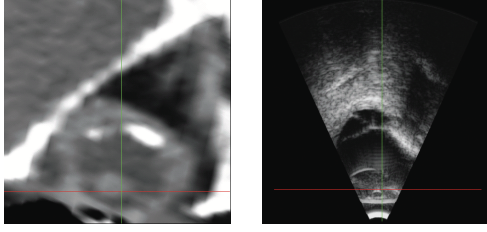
Resampled CT image to the US space and resolution, cross cursor represents the same spatial location.
